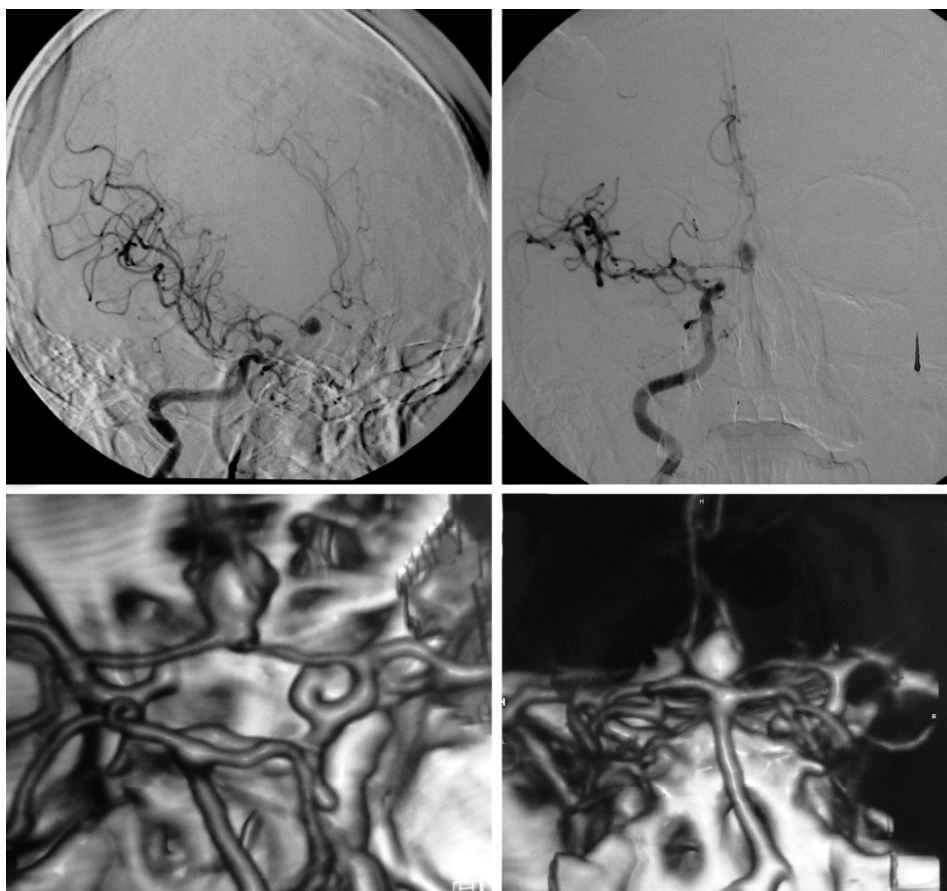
Digital subtraction angiography and computed tomography angiography— anterior communicating artery aneurysm
